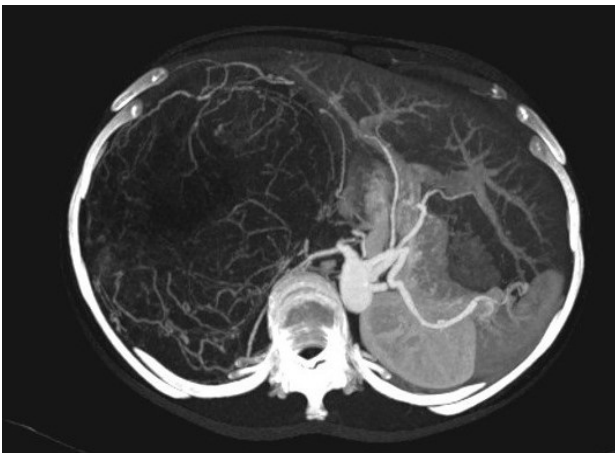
CT angiography, axial plane.
